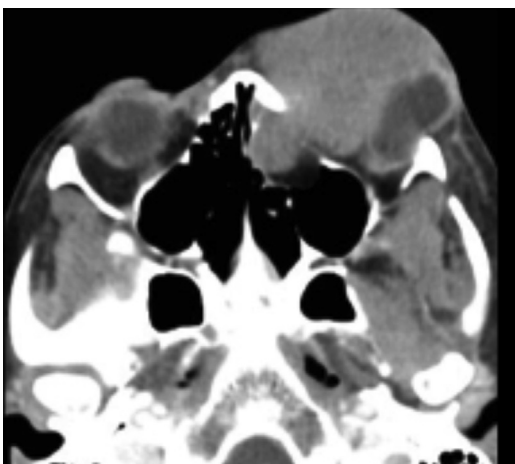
Axial postcontrast CT one month after initial CT scan with an interval increase in tumor size and increased mass effect on the globe.
